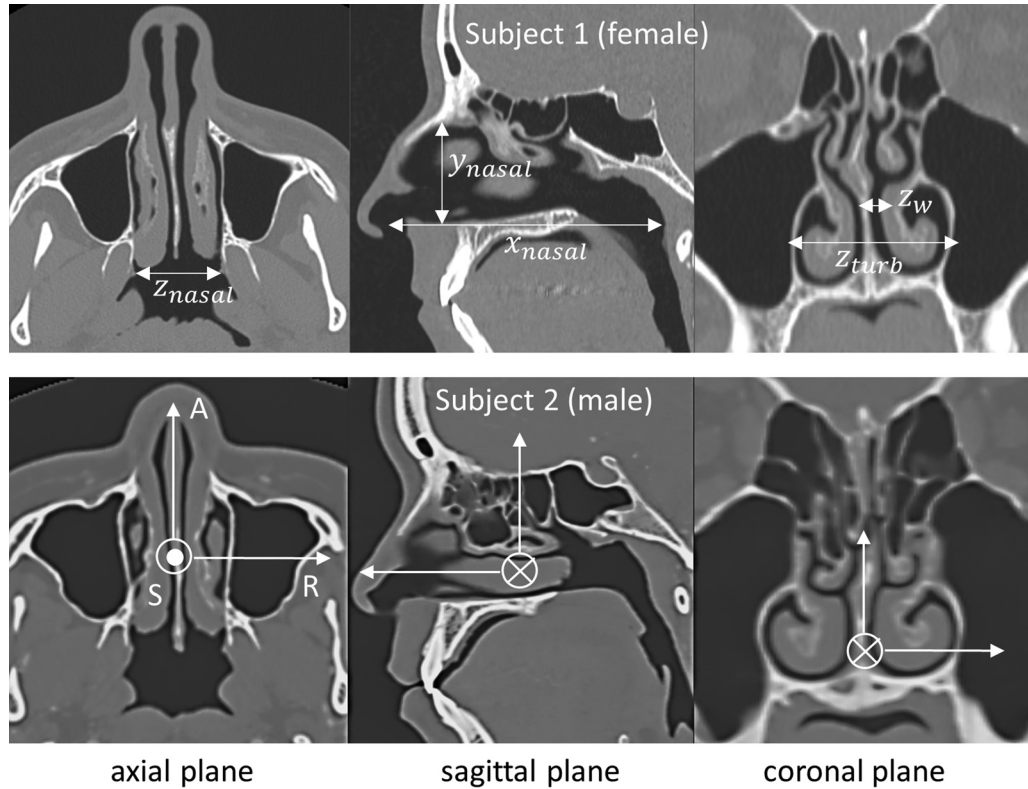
CT scans of subject 1 (female, top row) and subject 2 (male, bottom row). Axial, sagittal, and coronal planes are shown in the left to right columns. Images from subject 1 are annotated with the different length scales.
